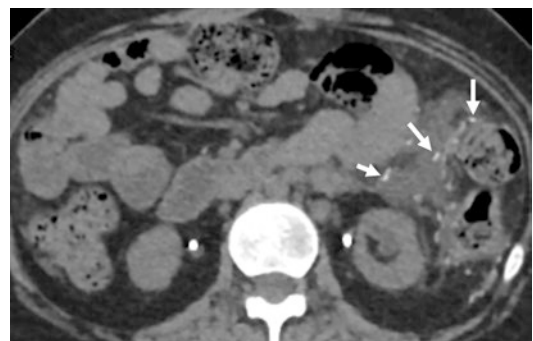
Calcifications in peritoneal tuberculosis. Axial unenhanced CT image shows multiple punctate calcifications (white arrows) within conglomerate peritoneal nodes, medial to the descending colon. (Courtesy of Dr. Ashok Mithra, Naruvi Hospital, Vellore, India)
